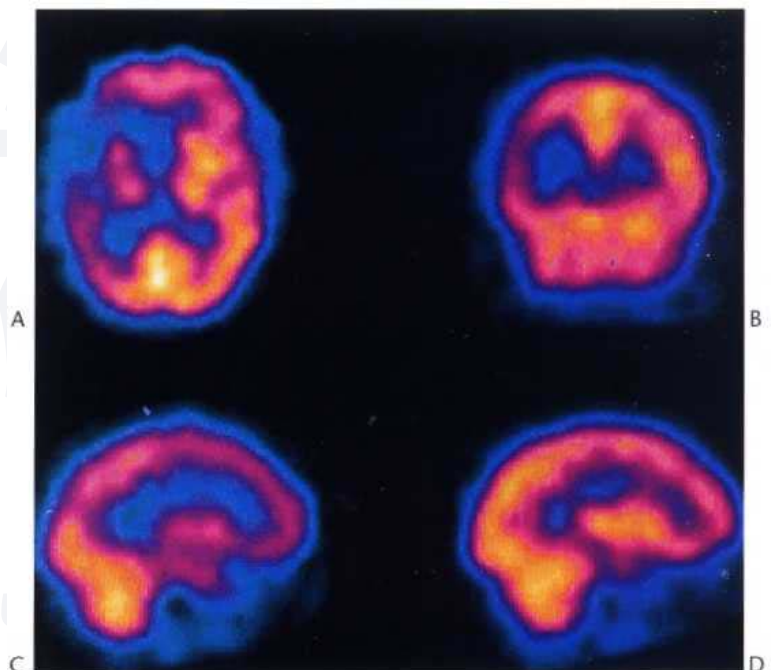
⁹⁹Tc-exametazime brain SPECT: axial (A), Coronal (B), right parasagittal (C) and left parasagittal (D) sections in a patient with massive infarction of the right middle cerebral artery territory. Note severe ischaemia of the frontal, temporal and parietal cortex and also of the basal ganglia on the right.
